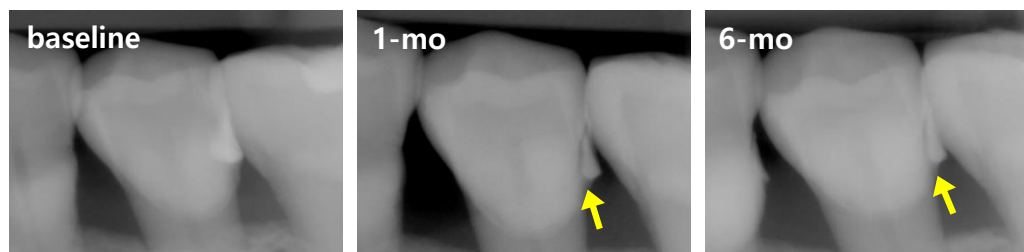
Radiographic image of a clinically unacceptable case in ‘radiographic examination’. CX restoration on tooth 35 of a 67-year-old female patient. A fracture line was detected (indicated by yellow arrows) from the one-month recall, resulting in score 5.
